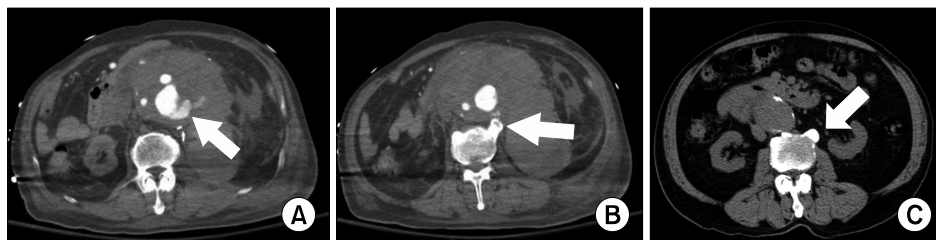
Transverse axial computed tomography images showing extravasation of the contrast agent into the retroperitoneal hematoma (A, arrow) and the bony spur (osteophyte) of the lumbar vertebral body (B, arrow). (C) The osteophyte was clearly visible in the preoperative image (arrow).
